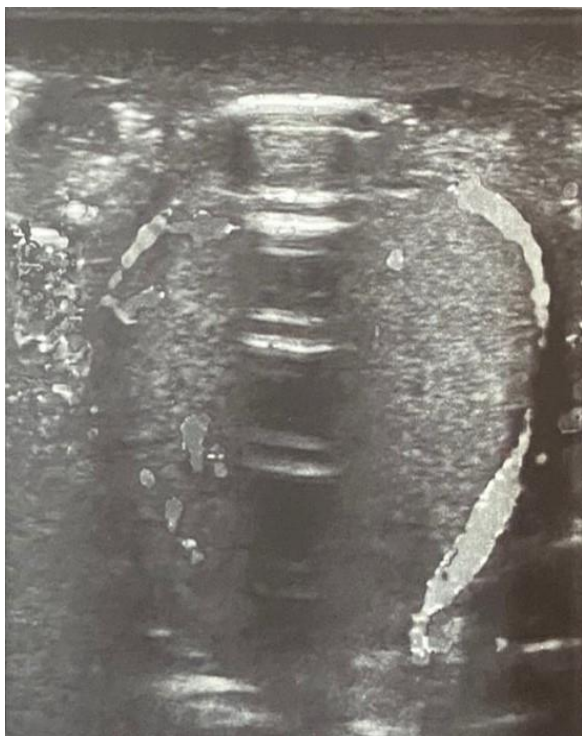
Ultrasonography of scrotum & perineum
